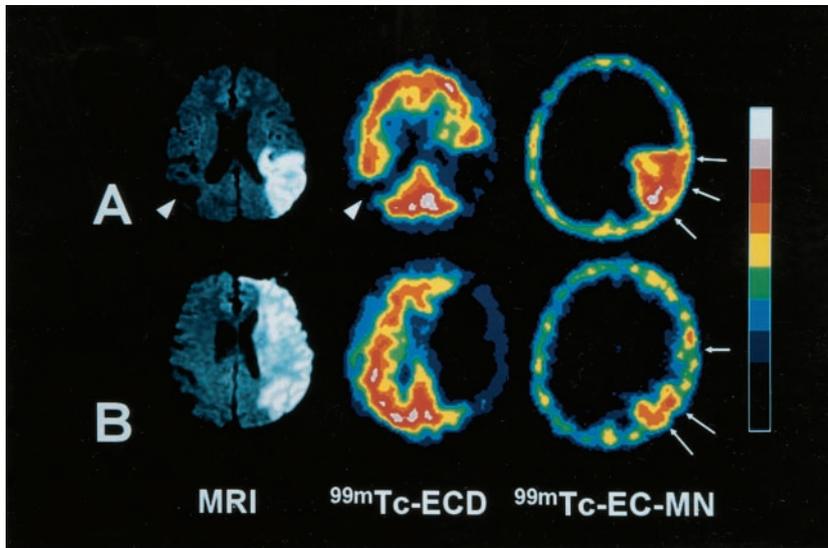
Two patients demonstrated large infarction areas on DW MRI and ^{99m}Tc-ECD brain SPECT. Patient 7 (A) showed an area of good uptake of ^{99m}Tc-EC-MN (white arrow) and had a 1-month NIHSS score of 1, despite the presence of an old infarction in the right parietal lobe (arrowhead) that showed no uptake of ^{99m}Tc-EC-MN. Patient 5 (B), on the other hand, showed an area of poor uptake of ^{99m}Tc-EC-MN (white arrow) and had a 1-month NIHSS score of 15.
